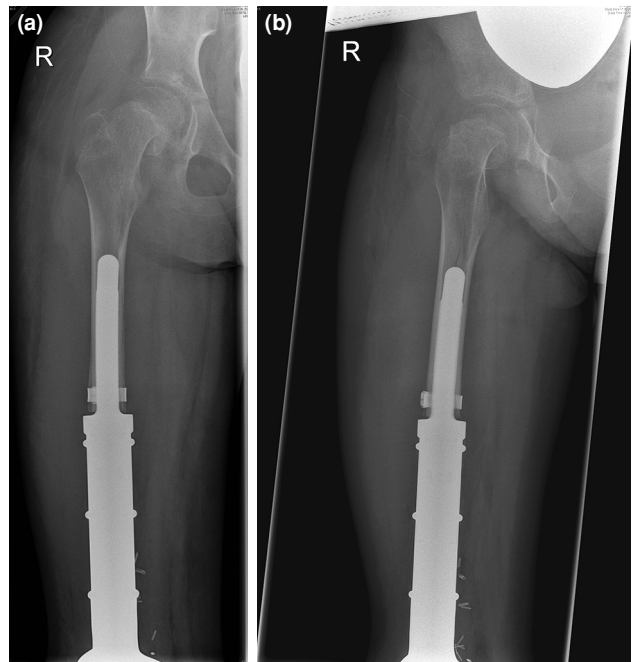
Revision surgery was performed using an HA-coated cementless femoral stem. Postoperative plain radiographs reveal an acute SCFE. (a) Anteroposterior radiograph (b) lateral radiograph. SCFE: Slipped capital femoral epiphysis.
